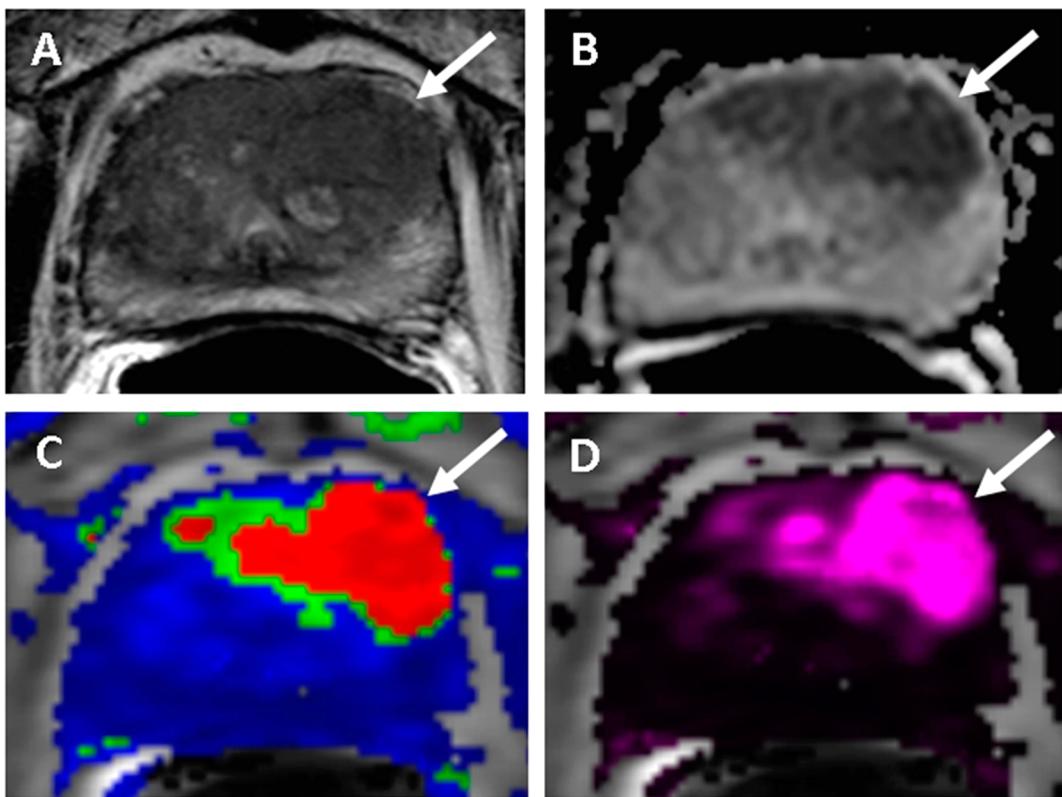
Images of a patient with high serum PSA (17.8 ng/mL) are shown. Axial T2W MRI (A) and ADC maps of diffusion weighted MRI (B) show a midline to the left anterior transition zone lesion in the mid prostate level (arrows). K_{trans} (C) and k_{ep} (D) maps generated from the DCE MRI data using a two-compartment model quantitative technique show an area of leaky vasculature that highly suggests cancer (arrows). Targeted biopsy revealed that highly malignant prostate cancer grew within the suggested lesion.
